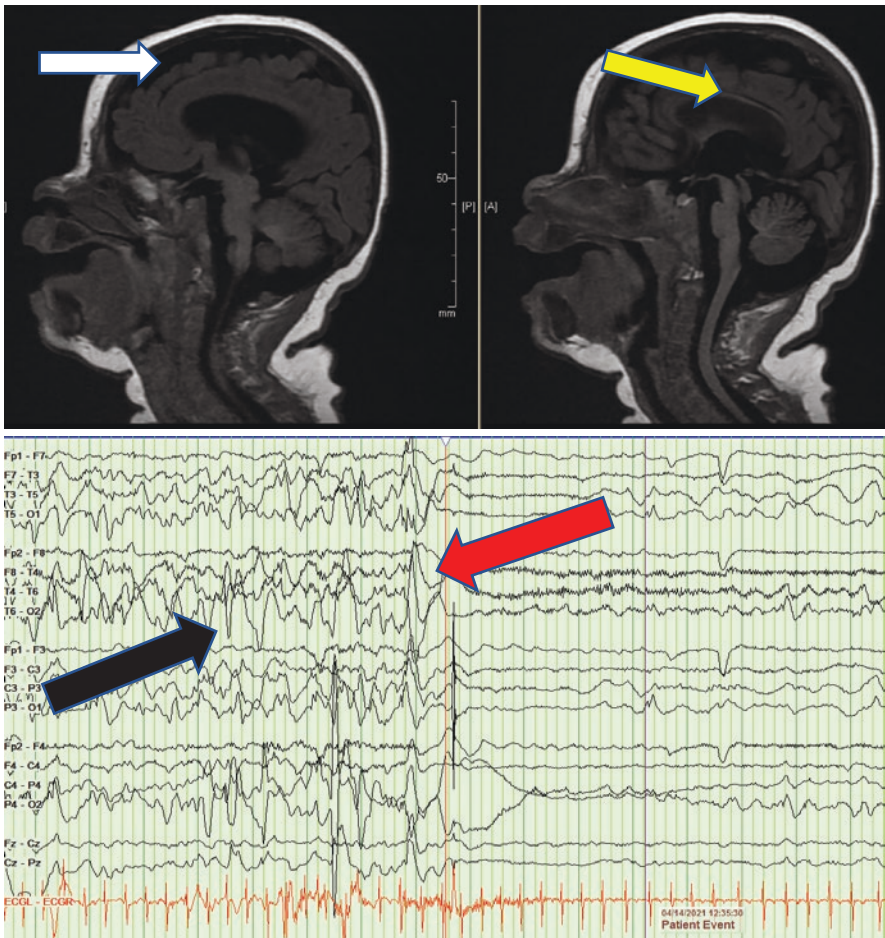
9-Month-old boy with microcephaly (white arrow on MRI image), ventriculomegaly, dysgenesis of corpus callosum (yellow arrow on MRI image). EEG showed hypsarrhythmia (black arrow) and captured an infantile spasm with electrodecremental (red arrow) response
